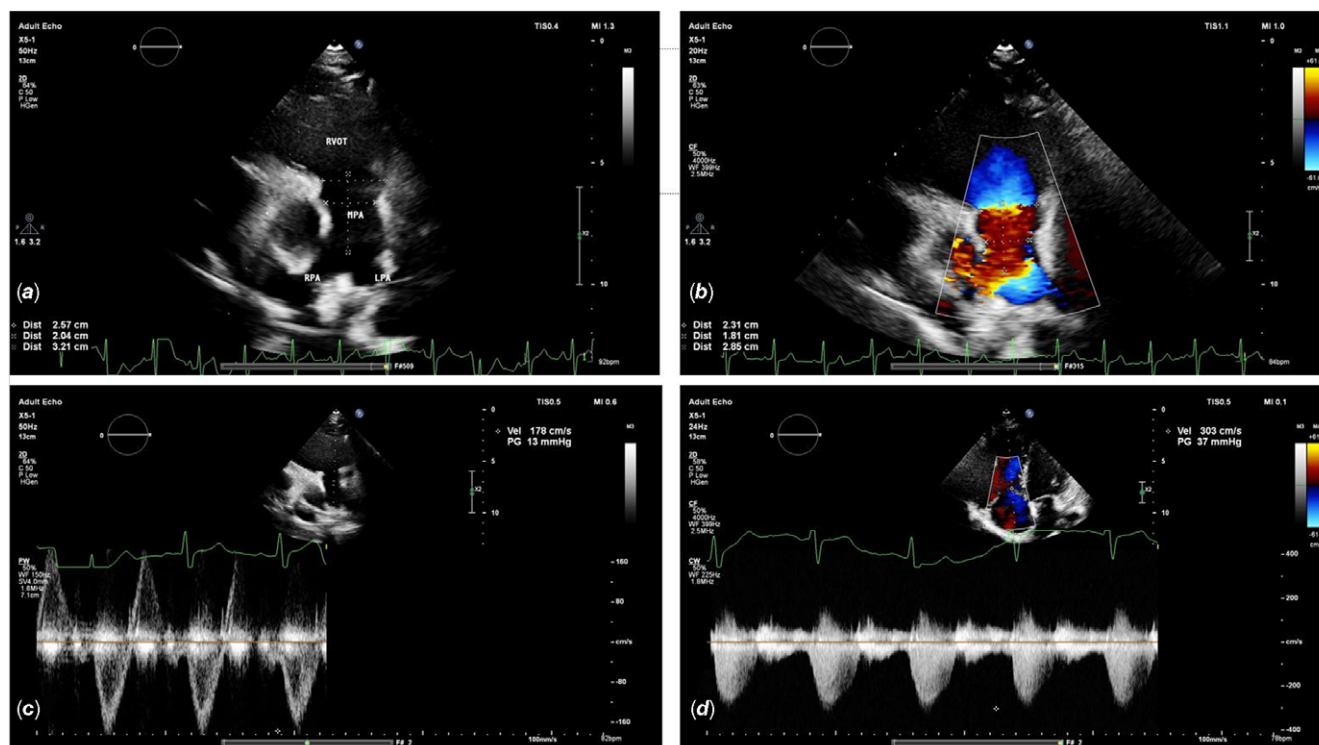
Detailed echocardiographic assessment of the heart before the procedure: Measurement of the pulmonary annulus, main pulmonary artery, and the length of the aimed implantation region in short axis view with 2D (a) and colour Doppler (b). Peak velocity with Continuous Wave Doppler throughout the right ventricle outflow tract (c). Tricuspid regurgitation velocity measurement (d).
